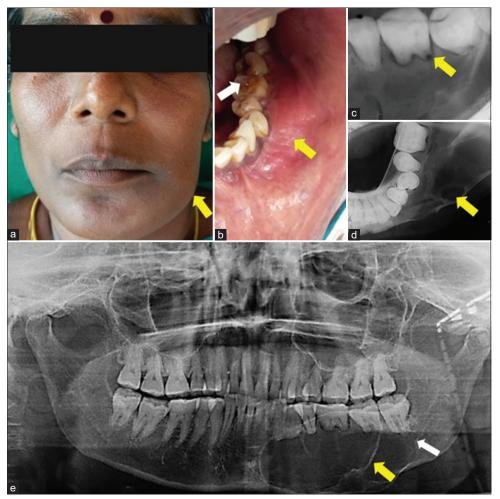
(a) Extraoral swelling in the left side of the mandible (yellow arrow); (b) intraoral swelling obliterating the left buccal vestibule (yellow arrow) and lingual inclination of teeth (white arrow); (c) periodontal ligament space widening, external root resorption in IOPAR; (d) Mandibular occlusal radiograph showing bicortical expansion, multilocular radiolucent appearance (yellow arrow); (e) orthopantomogram showing multiple radiopaque internal septa (yellow arrow), multilocular appearance and inferior alveolar nerve canal not well appreciated (white arrow)
